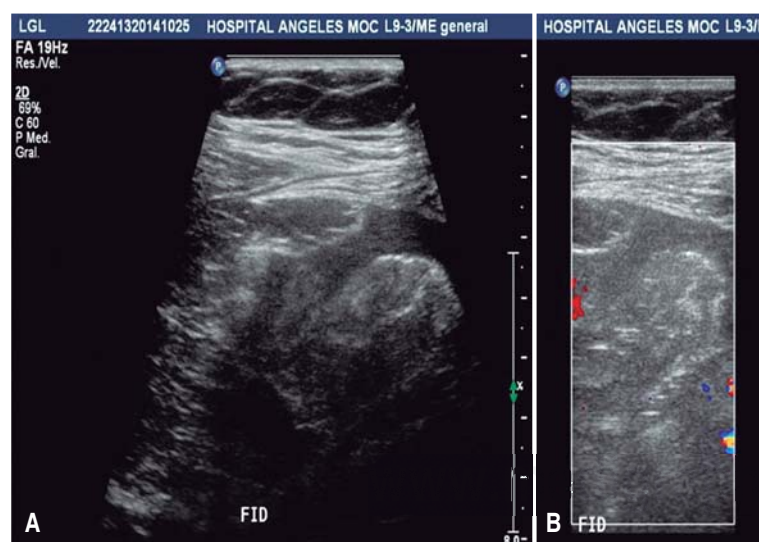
A. Abdominal ultrasound. In the RIF, at the caecum location, a bowel loop with slightly thickened walls and no peristalsis is visualized, as well as free fluid. B. With the use of color Doppler, no abnormal reinforcements are seen; inflammation of the appendix cannot be ruled out. Right ovary with an approximate volume of 18 cm³.
